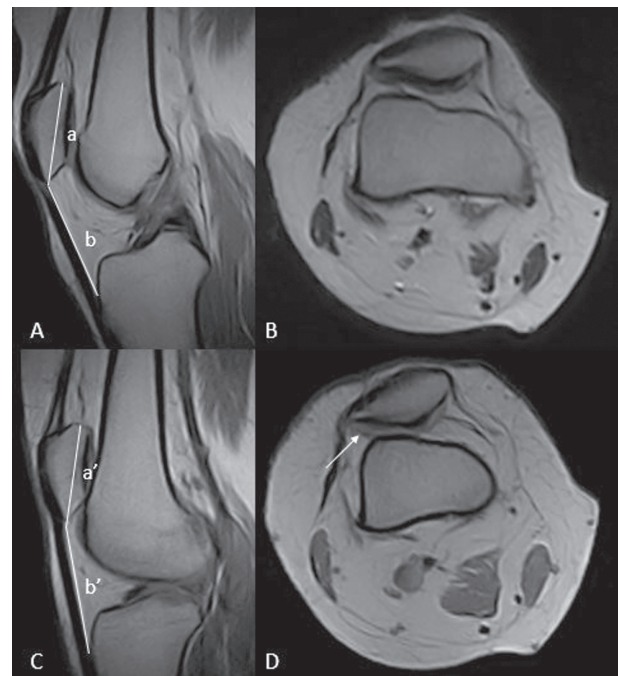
Sagittal and axial MRI images of the knee in standard supine (A, B) and weight-bearing position (C, D) of a patient with a high riding patella and patello–femoral instability. Under loading conditions, we can appreciate increase of the Insall–Salvati index (b/a ratio: 1.3; b'/a' ratio: 1.6) and lateral patellar subluxation (white arrow)
